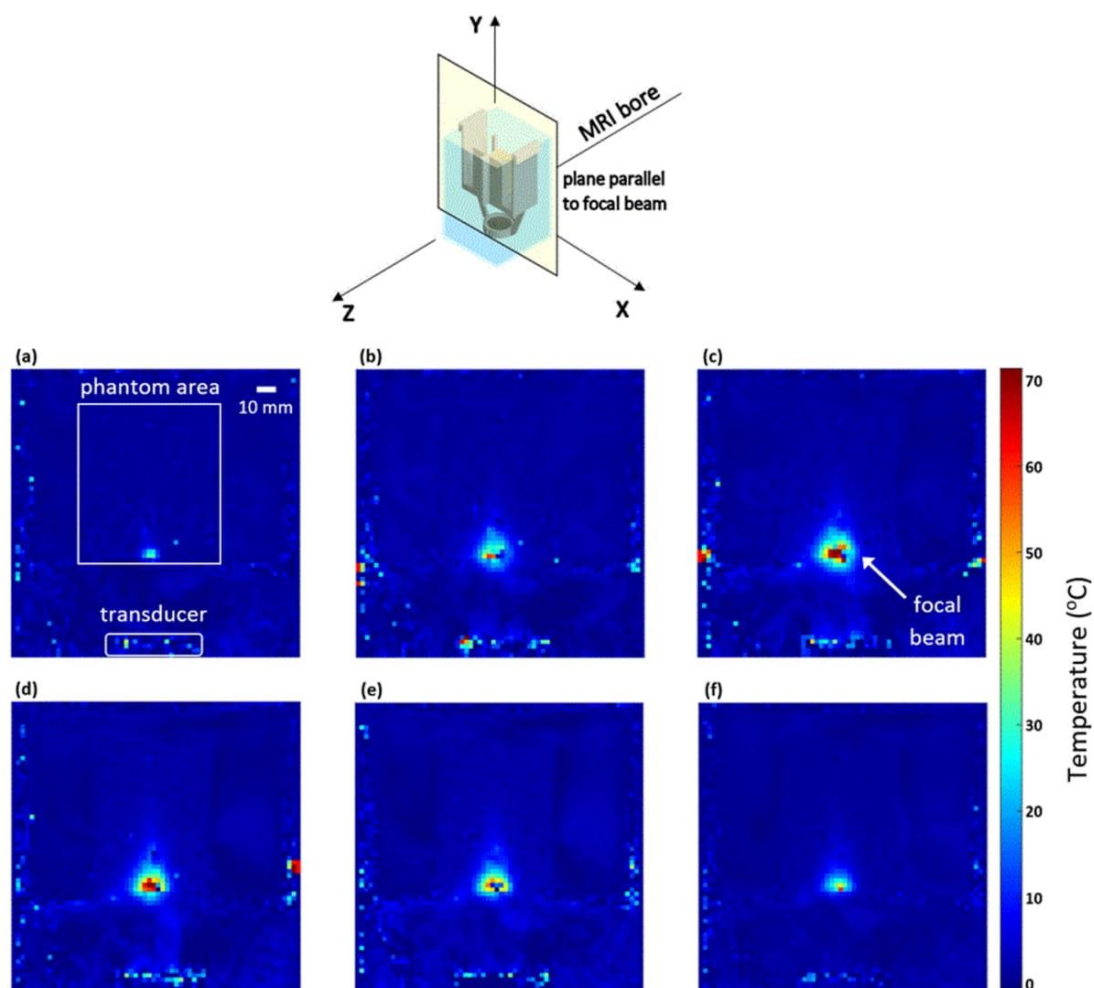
MR thermal maps obtained in a plane parallel to the beam at a focal depth of 2 cm for sonication time of (a) 5 s, (b) 15 s, (c) 25 s, and (d) 30 s and for a cooling time of (e) 10 s, and (f) 18 s, respectively. The plane of the MR thermometry maps taken in relation to the direction inside the MRI is indicated.
